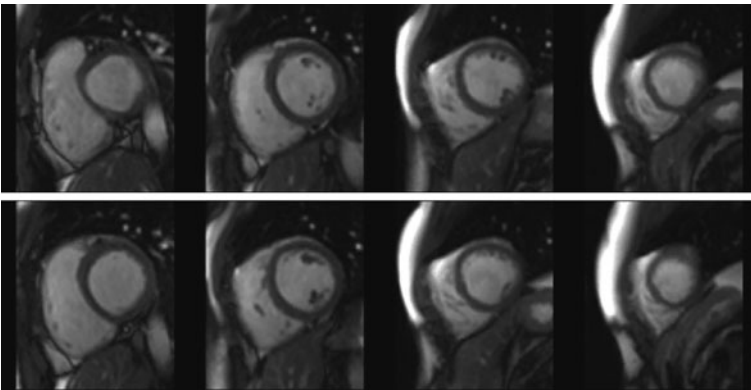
Sequence of cardiac MRI short-axis images of the left ventricle. Slices are shown from base to apex (*left to right panels*) in the diastolic phase of the cardiac cycle
